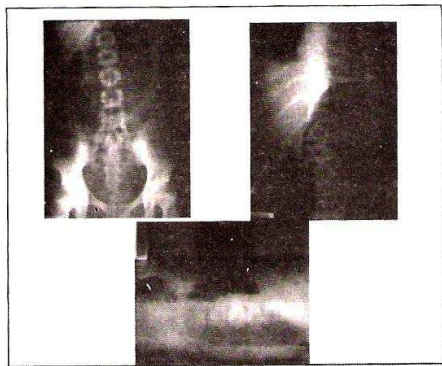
Three positional abdominal radiographic from Medika Lestari hospital
